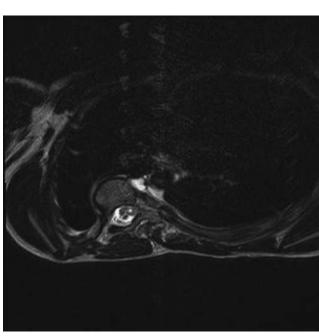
(A) Axial MRI scan through the apex of an idiopathic thoracic scoliosis, showing that the spinal cord lies close to the posterolateral elements on the concave side. (B) Sagittal MRI scan
